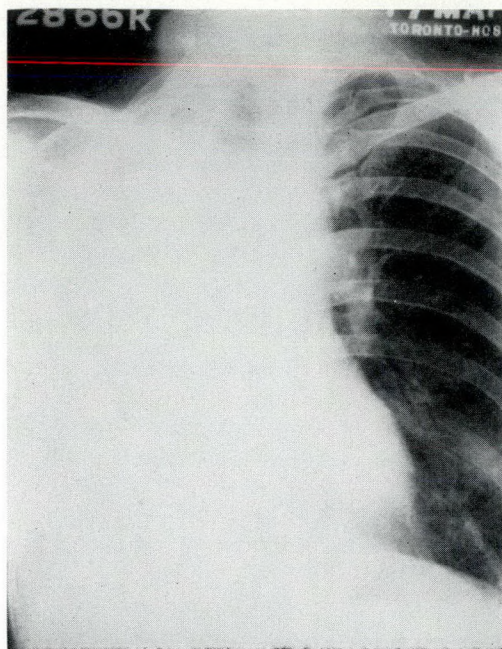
G.B. Chest radiograph May 17, 1968 showing a right pleuropneumonectomy.
